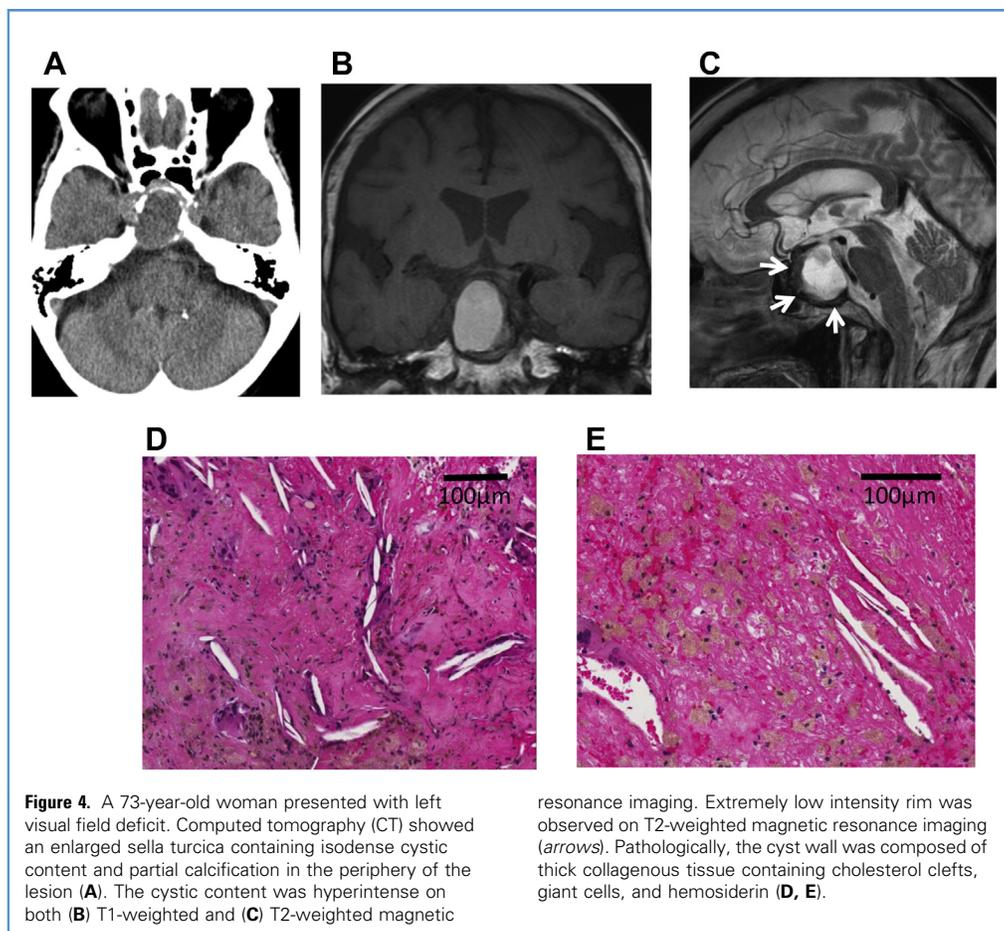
A 73-year-old woman presented with left visual field deficit. Computed tomography (CT) showed an enlarged sella turcica containing isodense cystic content and partial calcification in the periphery of the lesion (A). The cystic content was hyperintense on both (B) T1-weighted and (C) T2-weighted magnetic
